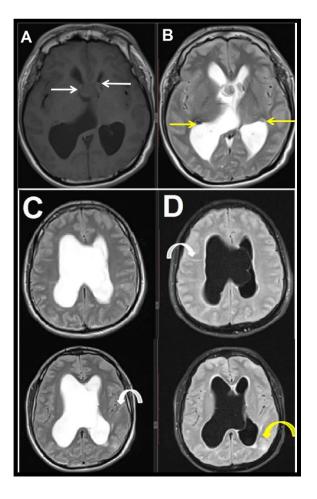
Cranial MRI, T1 (A) and T2 (B). There are two isointense intraventricular masses (white arrows) noted in the Foramen of Monro, largest of which is noted in the right side measuring 1.3 x 1.5 x 1.4 cm (CC x W x AP) and the other measuring 1.1 cm in widest dimension. The bilateral ventricles are dilated. There are small (approximately < 1 cm), irregular nodules (yellow arrows) along the ventricles. These nodules demonstrate variable signal likelv representing subependymal hamartomas (nodules) seen in TSC. On T2 (C) and FLAIR (D) sequences, there are linear bands radiating from the periventricular white matter to the subcortical region (an example is shown by the white curved arrows) likely representing radial migration bands which are thought to be specific for tuberous sclerosis. On the left posterior parietal region, there is a wedge-shaped high-signal focus on FLAIR likely representing a cortical tuber (vellow curved arrow).
